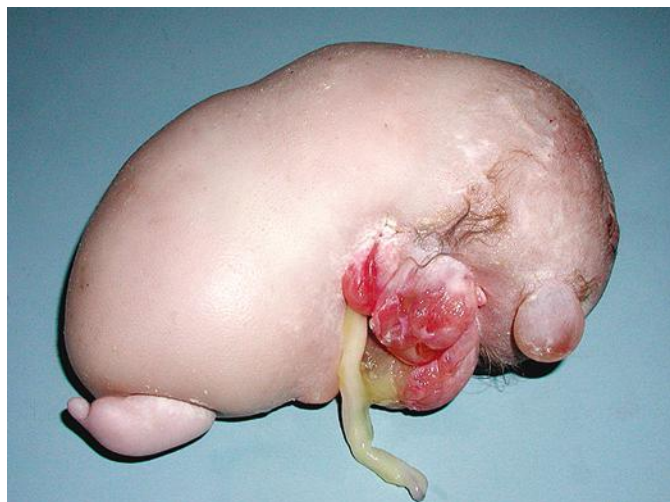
Acardiac twin demonstrating the amorphous, vestigial structures cephalad and caudad as the distance from the umbilical cord arterial circulation increases. (Pathologic image courtesy Melinda Sanders, MD, and Erika Walz, PA, University of Connecticut Health Center, Farmington, CT.)
